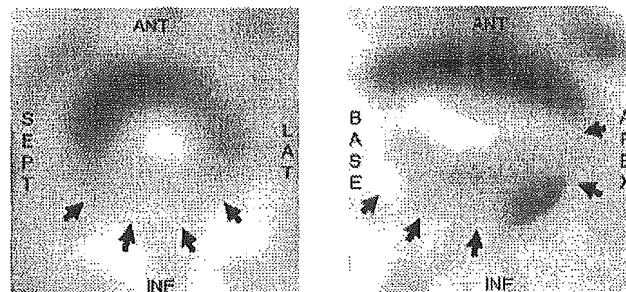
Clear defects of diffuse myocardial meta-iodobenzylguanidine (MIBG) uptake on iodide-123-MIBG single photon emission computed tomography (SPECT) imaging were observed (arrows). The left panel shows an axial view; the right panel shows an apical view of the left ventricle. ANT = anterior; LAT = lateral; INF = inferior; SEPT = septal.
